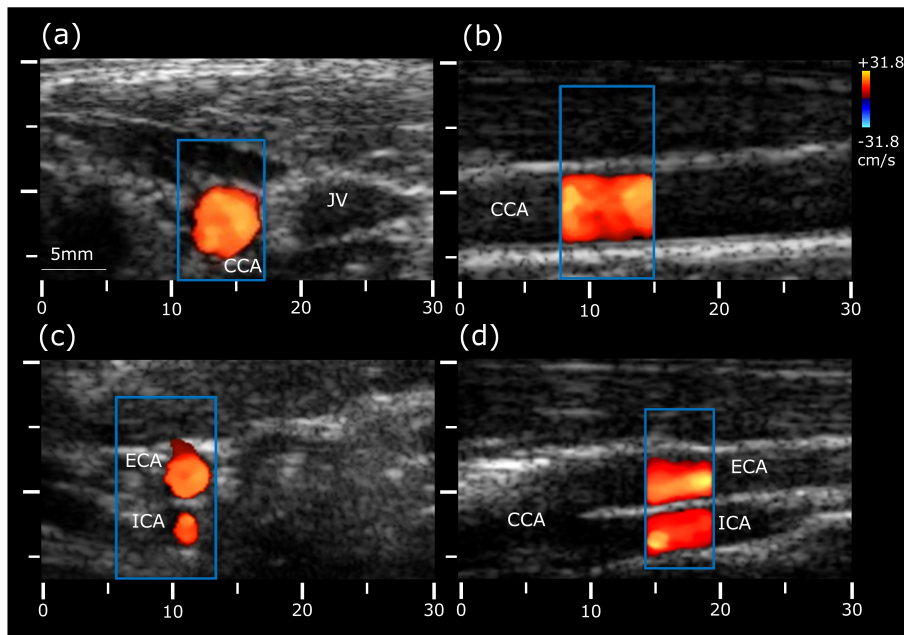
Color Doppler measurements of blood velocity in the carotid arteries and jugular vein. (a) Transverse and (b) longitudinal views of the common carotid artery; (c) Transverse and (d) longitudinal views of the carotid bifurcation into the external and internal carotid arteries. CCA: common carotid artery; ECA: external carotid artery; ICA: external carotid artery; IJV: internal jugular vein.
